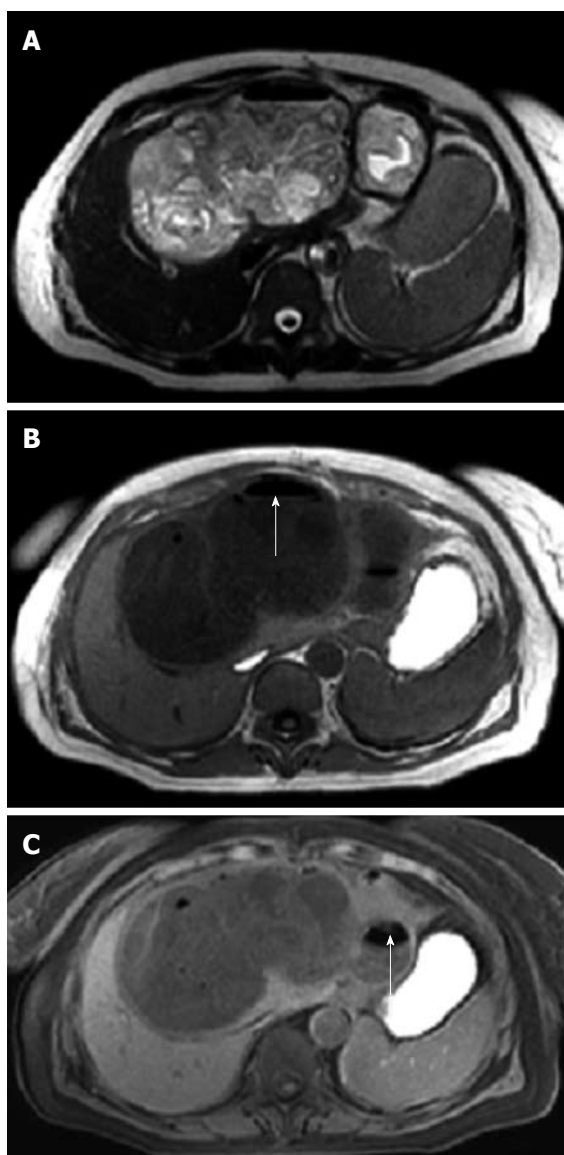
Axial T2-weighted (A) and T1-weighted (B, C) magnetic resonance images demonstrate a round, cystic lesion in the left hepatic lobe, with thickened pericyst, small daughter cysts, floating membranes and an air-fluid level within the cyst (white arrow). The diagnosis is an infected hydatid cyst (type IV).
